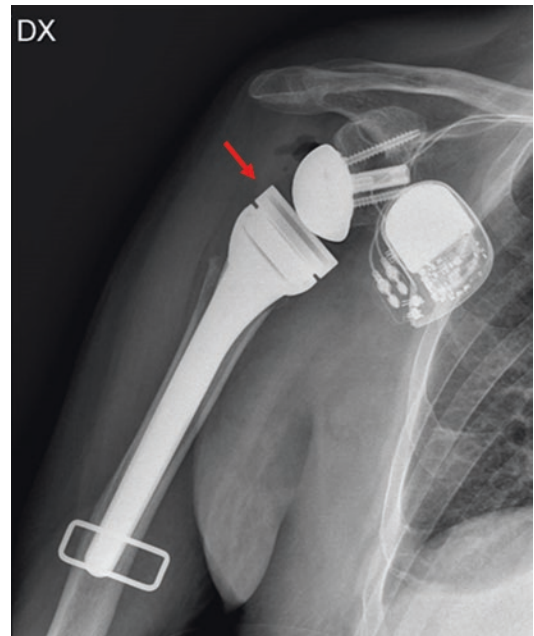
Postoperative radiographic control performed at our institution, showing correct position of the prosthetic components. Note the 9 mm spacer used as humeral augmentation (red arrow)
